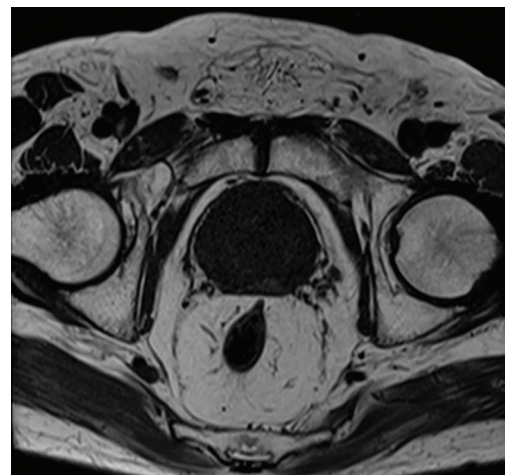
Magnetic resonance imaging at 3 months post-operation. The image showed that the prostate size ($5.2 \times 3.5 \text{ cm}^2$) was significantly smaller compared to pre-operation, indicating that the clinical symptoms improved
